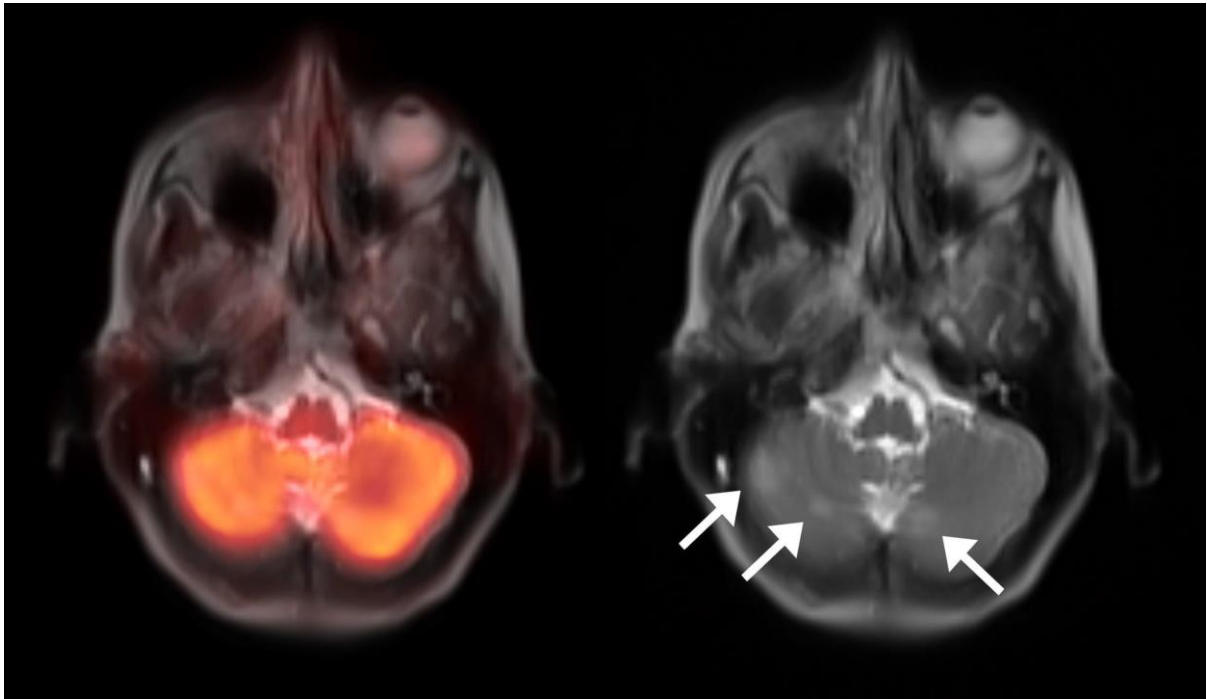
54-year-old female with breast cancer with no neurological symptoms. PET/MR axial fusion image (left image) shows no abnormal focal FDG uptake within the cerebellum. T2 haste axial demonstrates 3 new foci of hyperintensity within the cerebellar hemispheres that were suspicious for metastases (thin arrows). Other cerebral suspicious lesions were seen. Follow up dedicated brain MRI confirmed multiple cerebral metastases.
